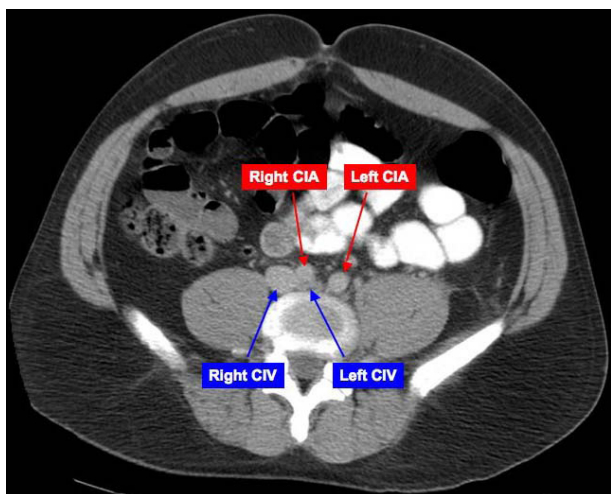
Axial plain abdominal CT reveals compression of left common iliac vein (left CIV) by right common iliac artery (right CIA)¹²
